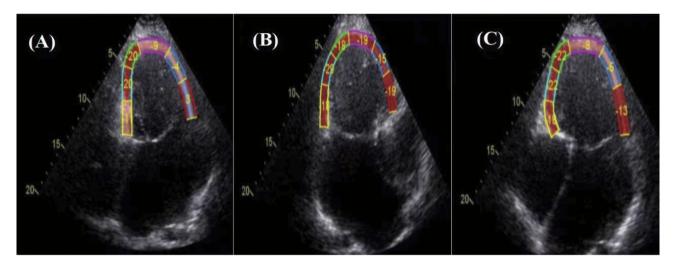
Images from 2D-STI of FSV. Images for two-dimensional speckle-tracking imaging of the functional single ventricle: (A) apical 2-chamber view; (B) apical 3-chamber view; (C) apical 4-chamber view. Abbreviations: FSV, functional single ventricle; 2D-STI, two-dimensional speckle tracking imaging
